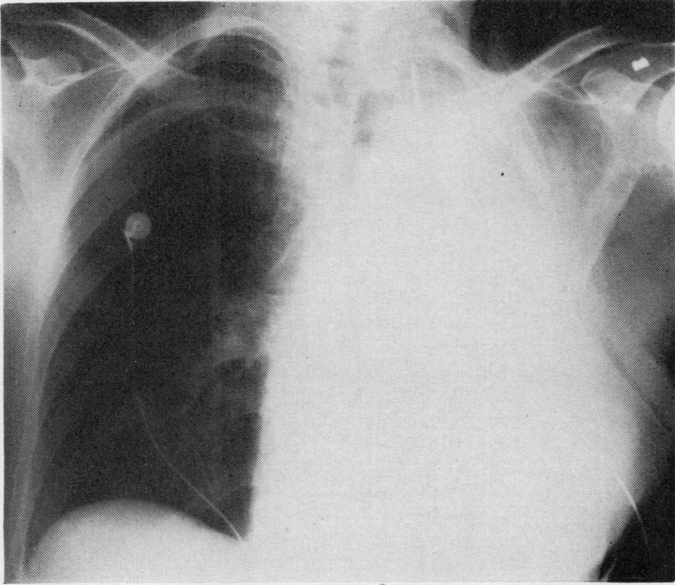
Chest radiograph taken approximately 12 hours after operation showing complete opacification of the left chest.
